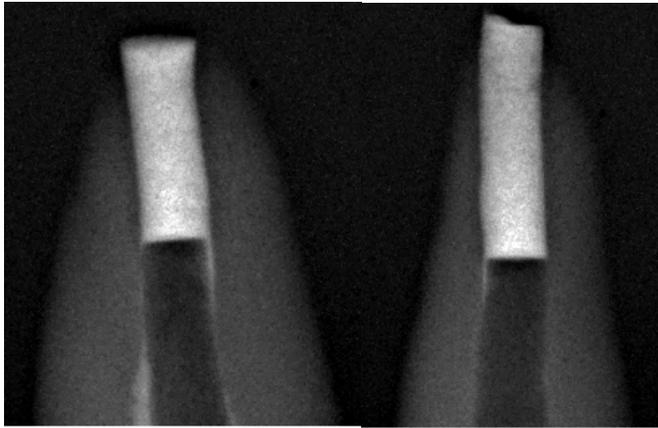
Radiograph showing placement of apical barriers
